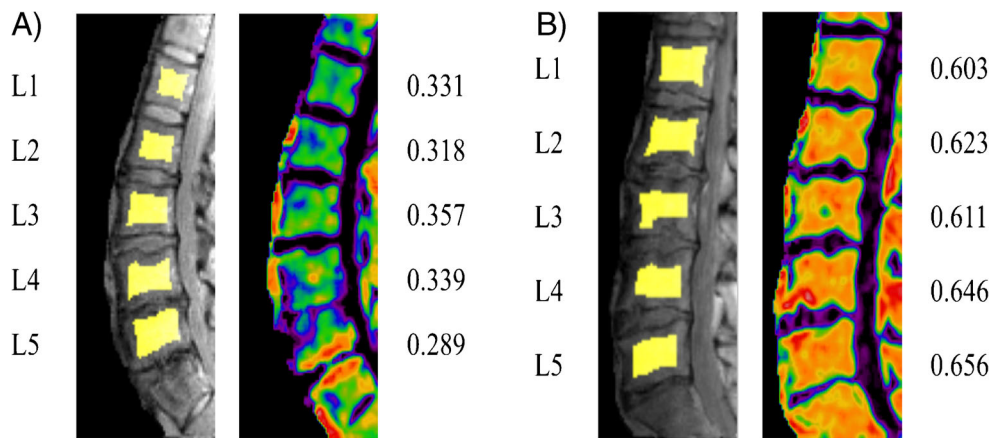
Chemical shift encoding-based water-fat imaging (CSE-WFI), showing sagittal images with the regions of interest and fat signal fraction map (SFF) of the lumbar spine of A a 52 year old postmenopausal female with low bone marrow adipose tissue (BMAT): SFF = 32.7% and normal bone mineral density (BMD quantified by quantitative CT): 129.1 mg/cm³ (normal BMD > 120 mg/cm³) and B a
